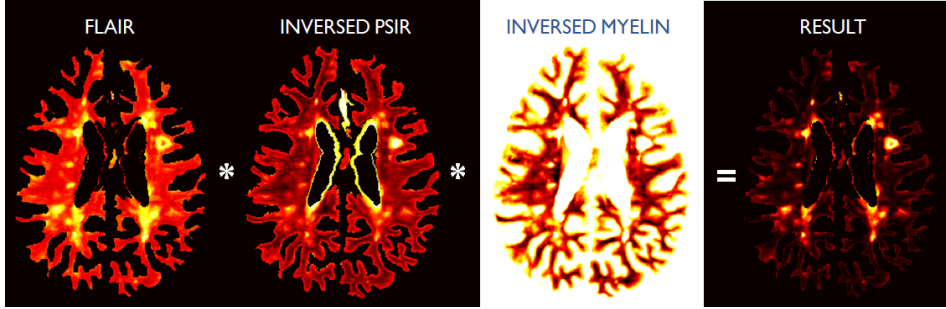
A multiplication of T2W FLAIR, inversed PSIR and inversed myelin tissue map were used to enhance the lesions
